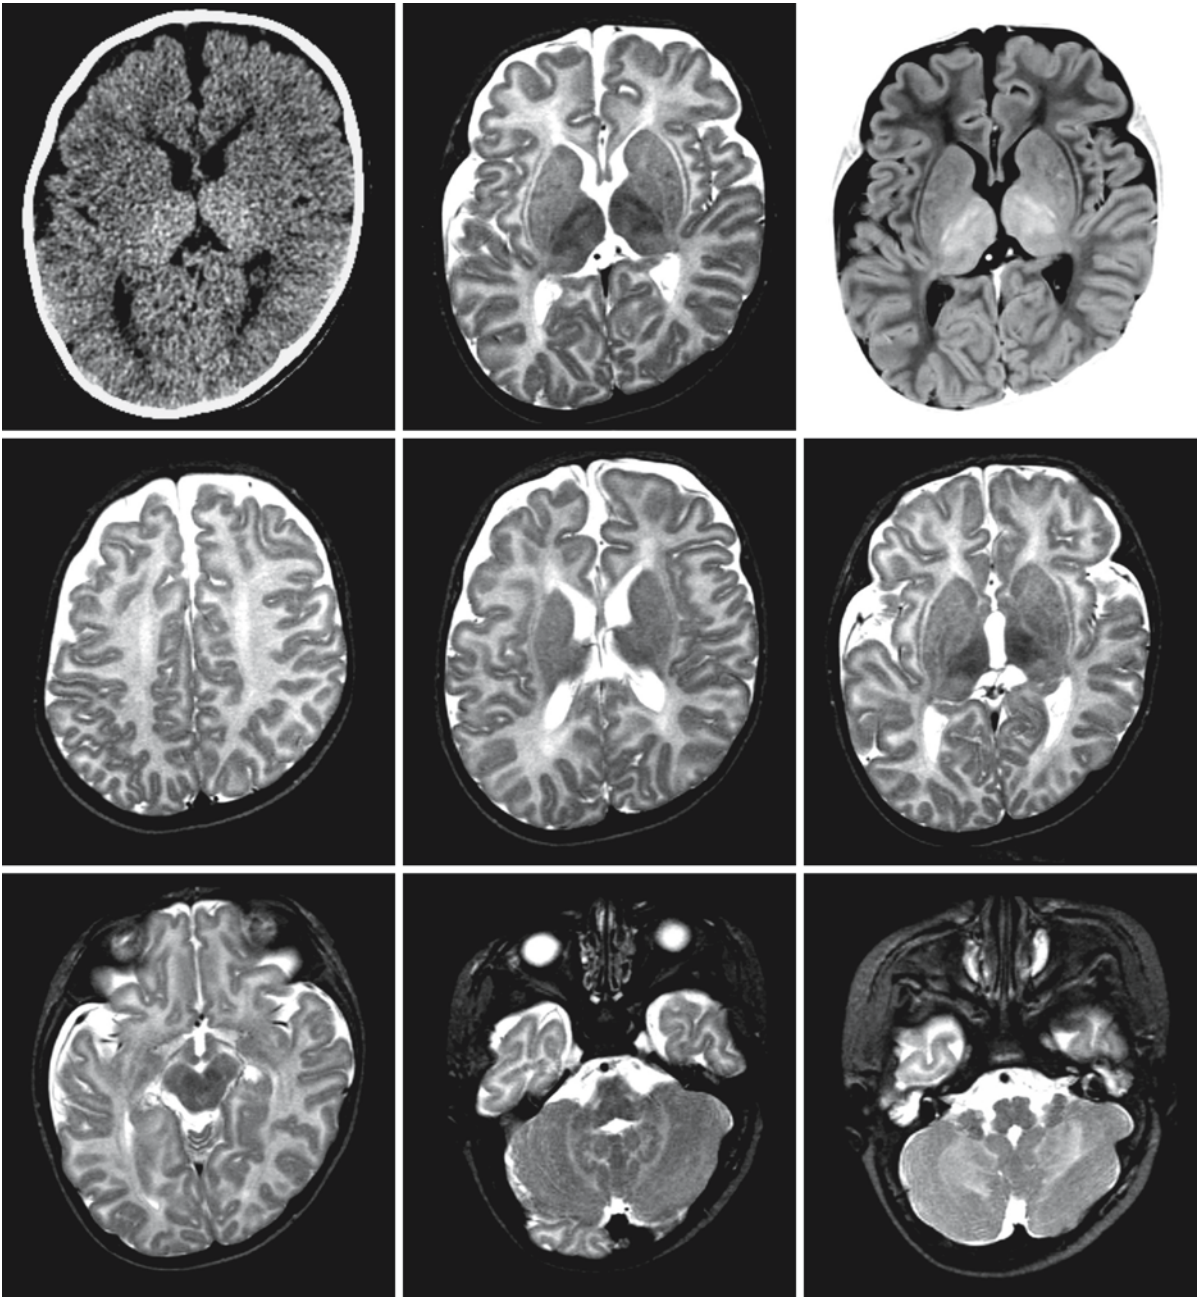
CT scan and MR images in a 7-month-old boy with type 1 GM₁ gangliosidosis. Note the high density of the thalamus on CT. The thalamus and basal ganglia are diffusely slightly abnormal on both T₁- and T₂-weighted MR images (*first row*).
